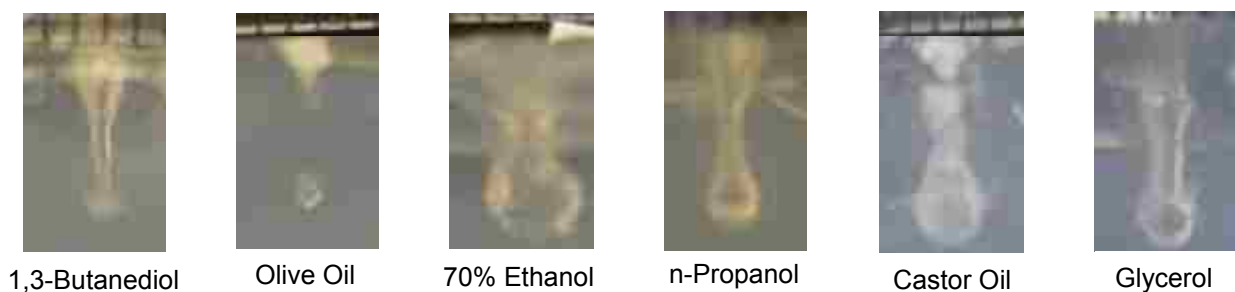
Photographs showing the holes in polyacrylamide gel when the surface was wetted with 1 of 6 liquids after an exposure to 60, 10-ms pulses repeated at 1 Hz delivered with 2 MHz ultrasound operating at $24,000 \text{ W/cm}^2$. For all exposures, the transducer was positioned at the bottom of the page and pointing towards the top of the page (the free gel surface). While the scales are similar for these photographs, the camera angle differs between the gels. For example, the hole in gel when wetted with 70% ethanol was only 3 mm deep, while the hole in castor oil extended 6 mm into the gel, even though in the photographs, the depths look similar. The measured dimensions of the eroded gel volumes are included in table 4.4.
